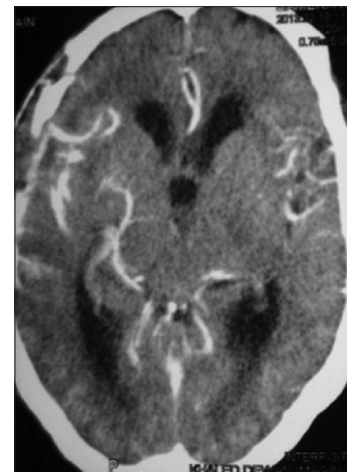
Postoperative computed tomography angiography revealing a patent radial artery graft with improvement in circulation in the right hemisphere as compared to the left after carotid ligation
